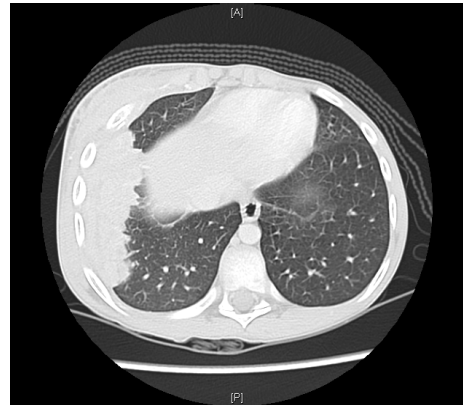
Computed tomography (CT) scan that shows periosteal reaction and destruction
